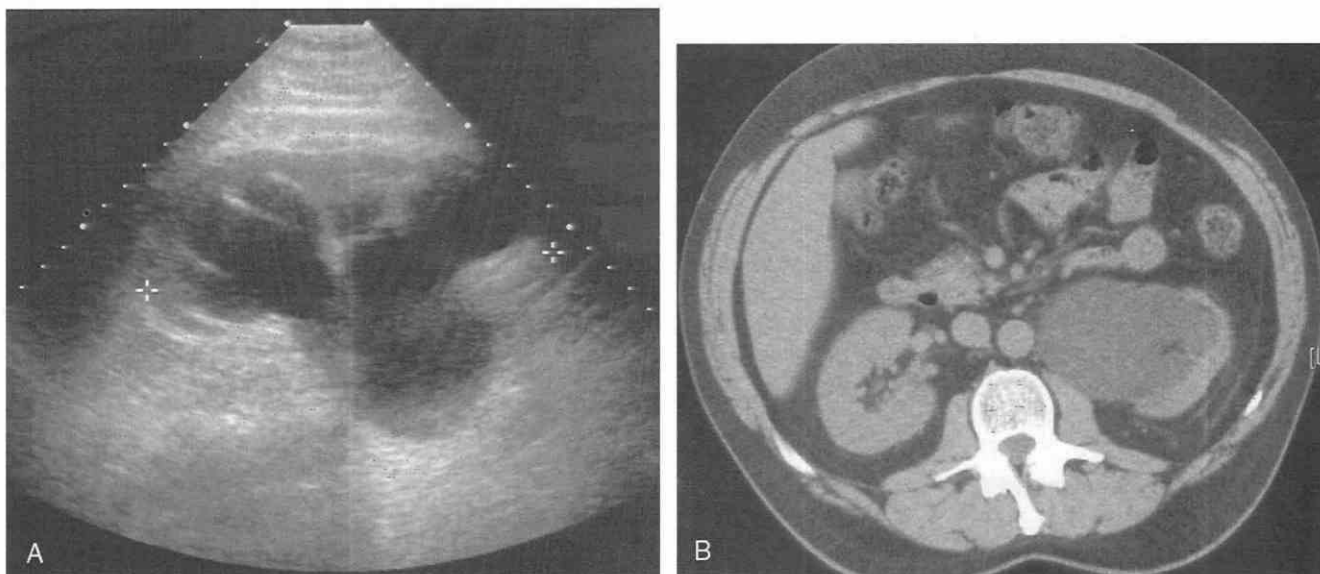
Congenital ureteropelvic junction obstruction. *A*, Longitudinal sonogram of left kidney shows marked hydronephrosis with medial tapering of the renal pelvis. *B*, Corresponding CT scan reveals the medial tapering of the renal pelvis and marked hydronephrosis. The ureter beyond the junction was collapsed. The patient underwent pyeloplasty.
